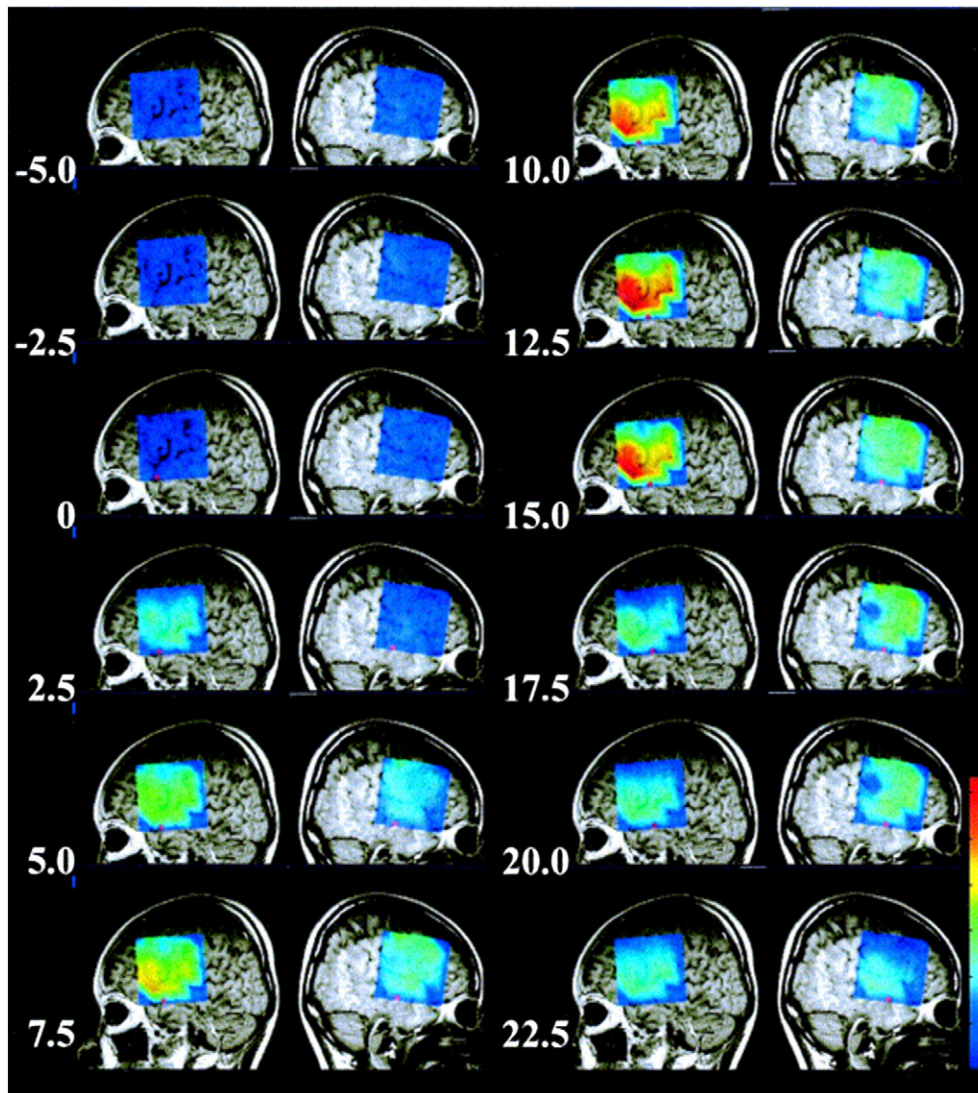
Serial contour pseudo color maps of total hemoglobin changes obtained by a 24-channel (12 on each hemisphere) continuous wave system (Tokyo Hitachi Ltd. Central Research Laboratory). The maps are overlaid on the lateral MRI surface image of the subject. Total hemoglobin increased after the beginning of the task (a 17-s word generation) and gradually decreased at its end. The largest increase was observed in the left inferior frontal area which is in the vicinity of the Broca's area. The numbers indicate the time in s (being time 0 the beginning of the task).
